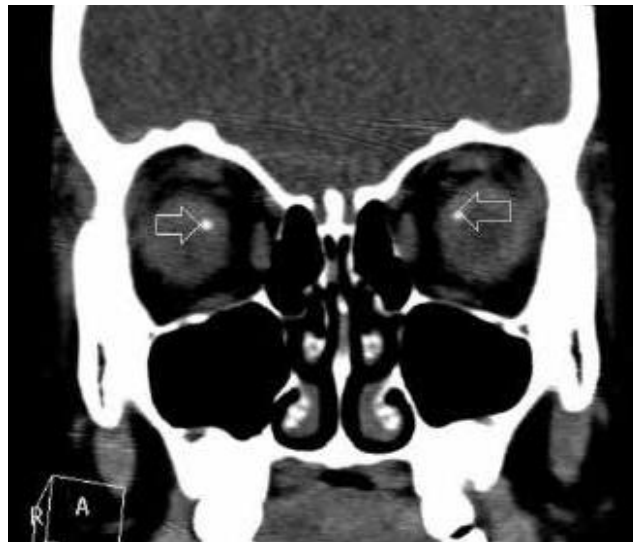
⁸ Transverse CT of orbits revealing drusen (small dense white masses as indicated by arrows)
